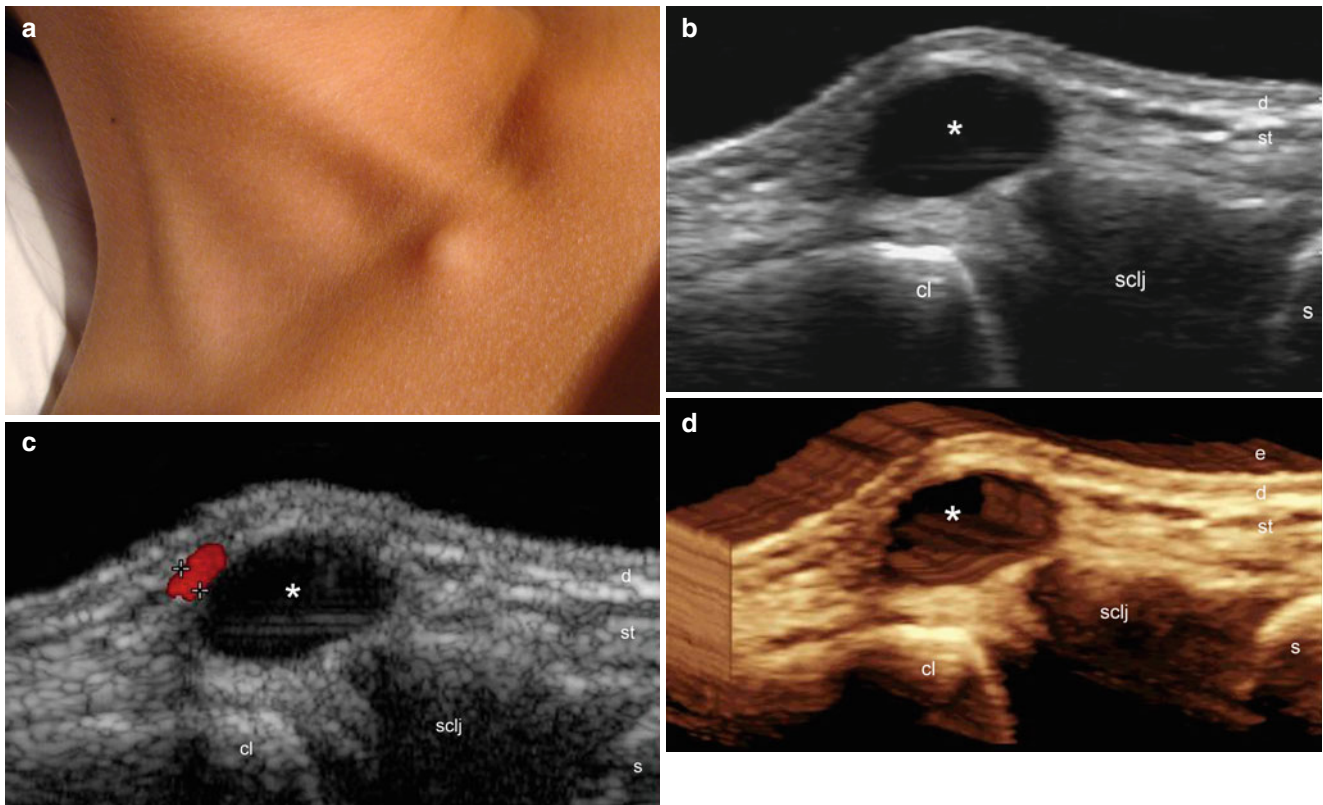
(a–d) Synovial cyst. (a) Clinical figure shows a skin-colored lump in the right upper sternal region. (b) Grey scale ultrasound image (transverse view) demonstrates a well-defined, oval-shaped, anechoic structure (*) in the subcutaneous tissue that is attached to the sternoclavicular joint (sclj). (c) Color Doppler ultrasound image (transverse
